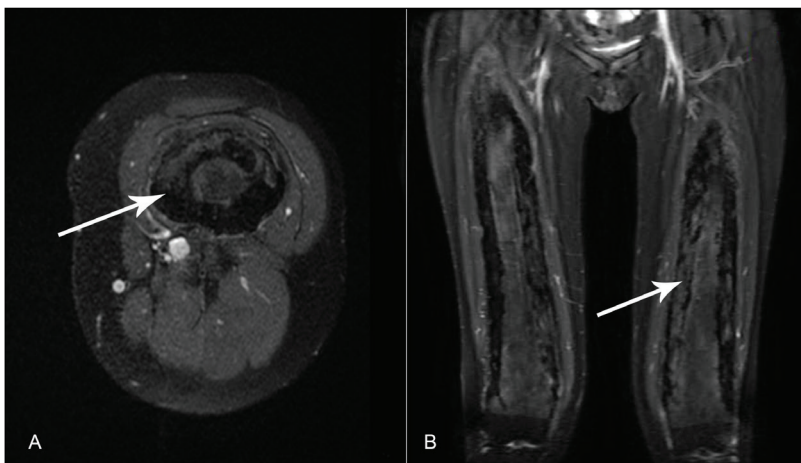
A. T1-weighted fat-suppressed cross-section of the left thigh after the intravenous injection of paramagnetic contrast agent. Note the thickening and heterogeneity of the femoral cortex (arrow). The adjacent muscles and subcutaneous tissue are preserved. B. T2-weighted fat-suppressed coronal section of the thighs showing increased diameter of both femurs with irregular thickening of the cortical bone, diffuse central and medullary edema (arrow).
